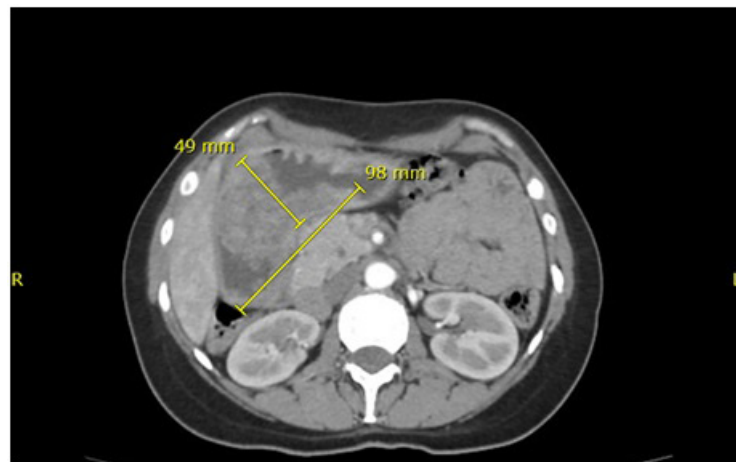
Contrast enhanced abdominal computed tomography (CT): arterial phase
